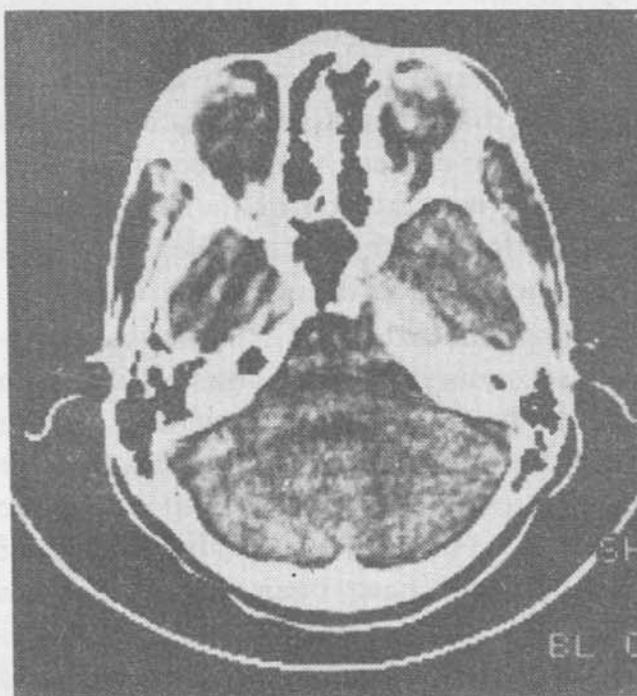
Contrast CT scan showing a high attenuating mass in the region of medial portion of petrous bone.
